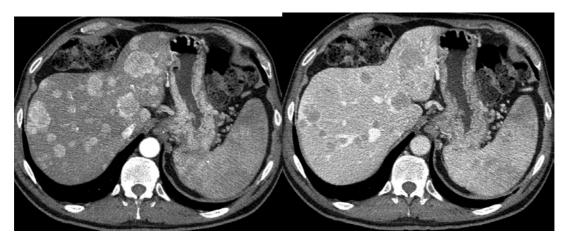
Multiphase CT scan shows multiple liver metastasis of a neuroendocrine tumor, which present enhancement in the arterial phase and wash-out in the venous phase
